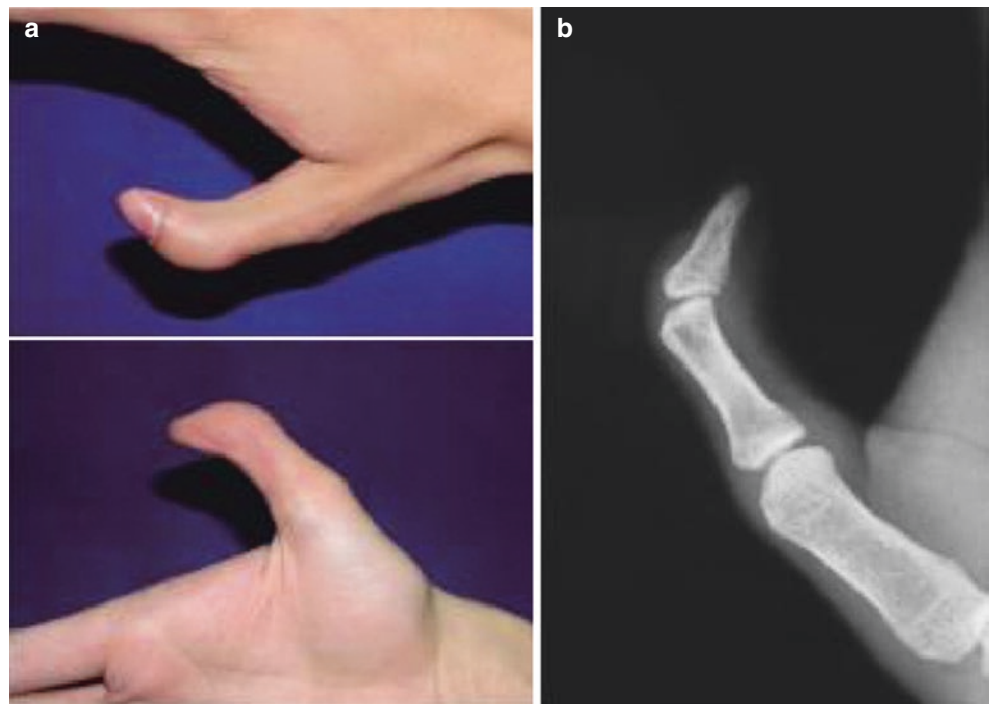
Bilateral deformities of thumb deviation. (a) The child's father suffers thumb deviation and polydactyly. (b, c) X-ray film indicates heterauxesis of the thumb delta phalange and epiphyseal plates
